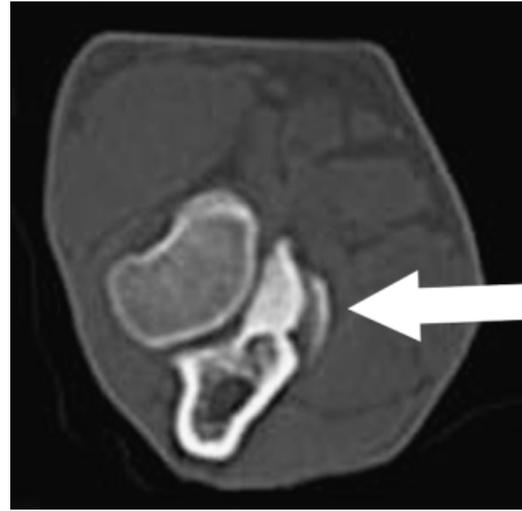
Transverse computed tomography (CT) image of sclerosis of the medial coronoid process (MCP) and proliferation (arrow).
